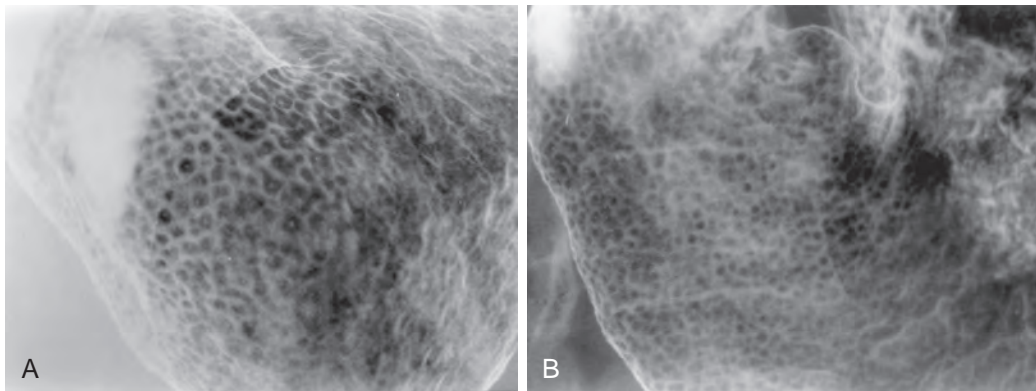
H. pylori* gastritis with lymphoid hyperplasia. A, B. In both patients, enlarged lymphoid follicles are seen as innumerable tiny, round nodules that carpet the mucosa of the gastric antrum. In A, note how many of the nodules have central umbilications with punctate collections of barium seen en face in the lesions. (From Torigian DA, Levine MS, Gill NS, et al: *Lymphoid hyperplasia of the stomach: Radiographic findings in five adult patients. AJR 177:71-75, 2001.*)
